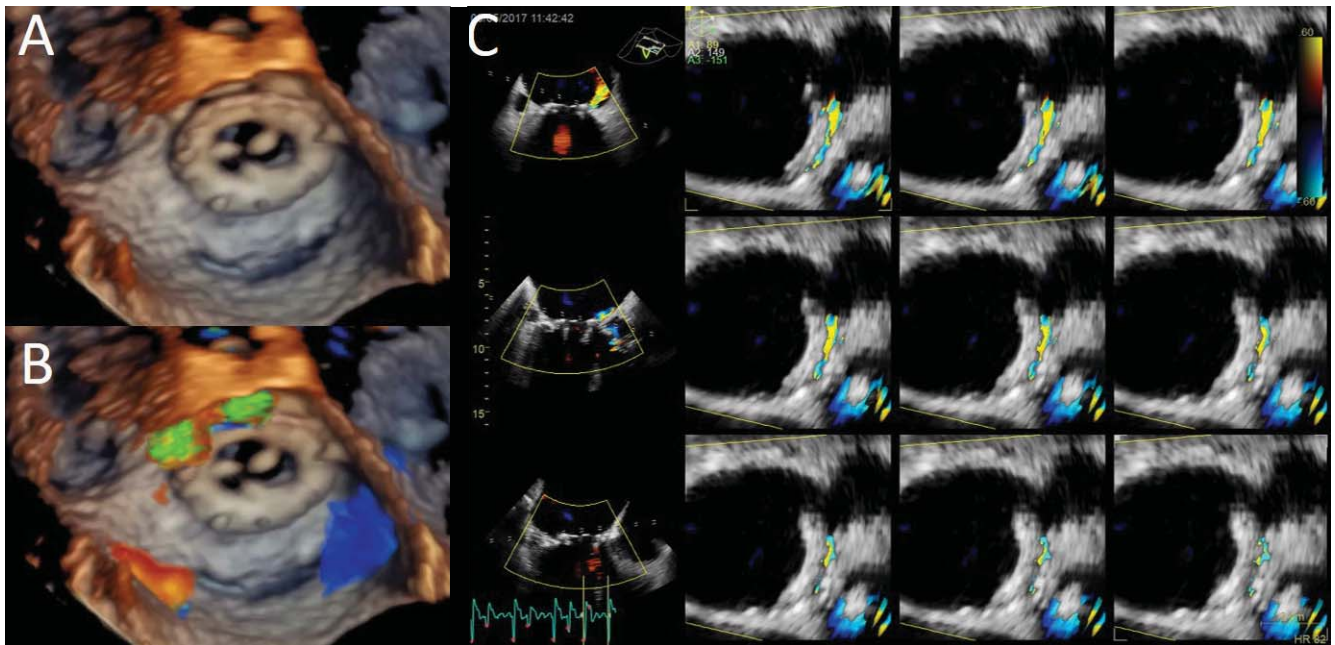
Mitral periprosthetic regurgitation. Three-dimensional transesophageal volume rendering (Panel A) and colour flow acquisition (Panel B) showing anterolateral periprosthetic regurgitation (between 10-12 o'clock). Multi-slice display to allow planimetric quantitation of the regurgitant orifice (Panel C).
